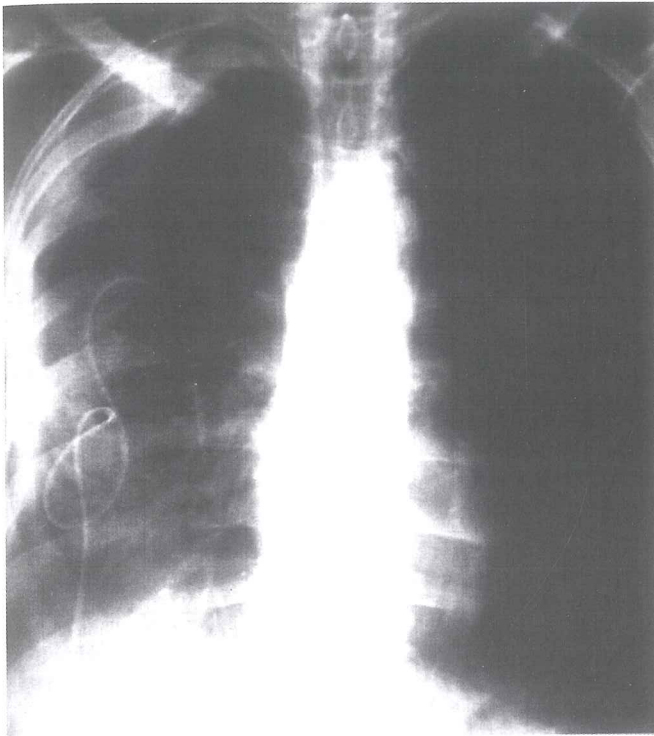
Follow-up chest X-ray. Note the pleurocan catheter inserted into the right hemithorax to drain the effusion.
